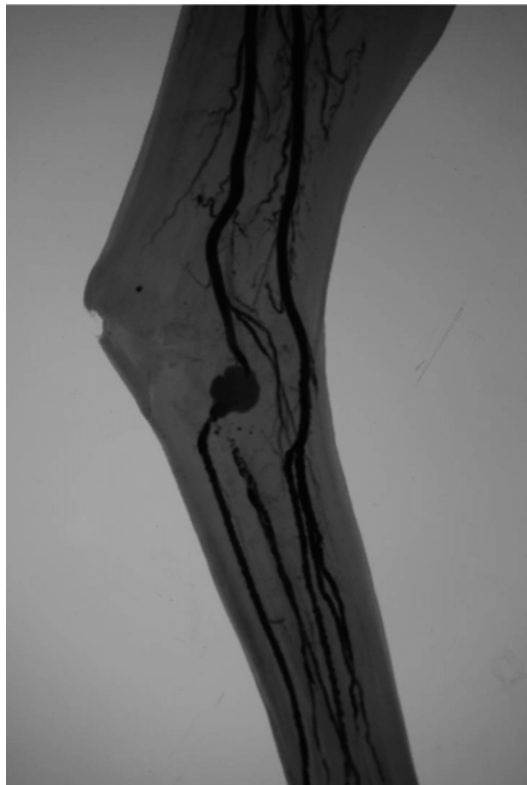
CT angiography showing popliteal artery aneurysm. Patient presented with ulceration of foot
